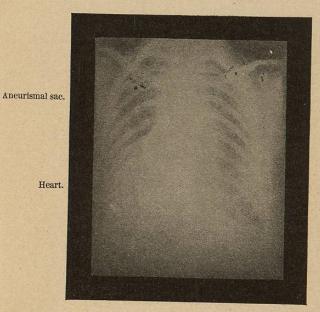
Aneurismal Sac Radiographed from Behind.
